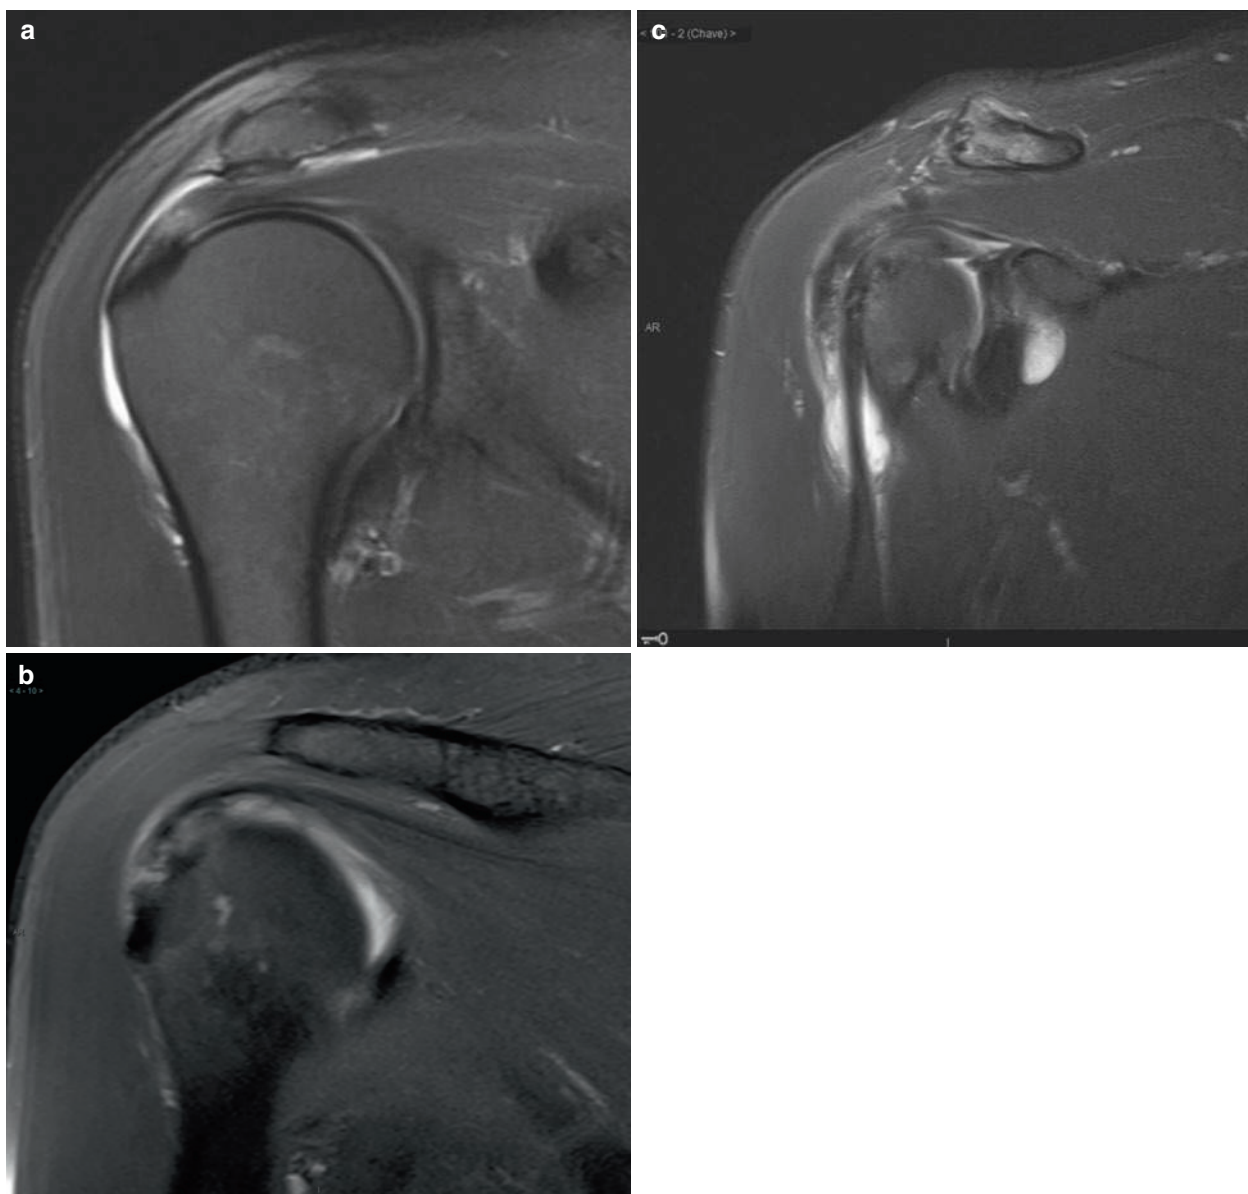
Coronal oblique T2-weighted fat suppressed images showing subacromial bursitis and tendinosis of supraspinatus (a), infraspinatus (b) and intra-articular portion of long head of biceps tendon (c)
